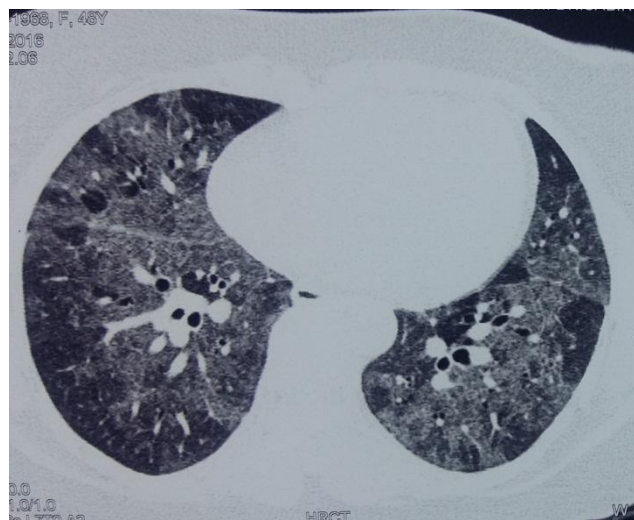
Nonspecific interstitial pneumonia type ILD on HRCT thorax
